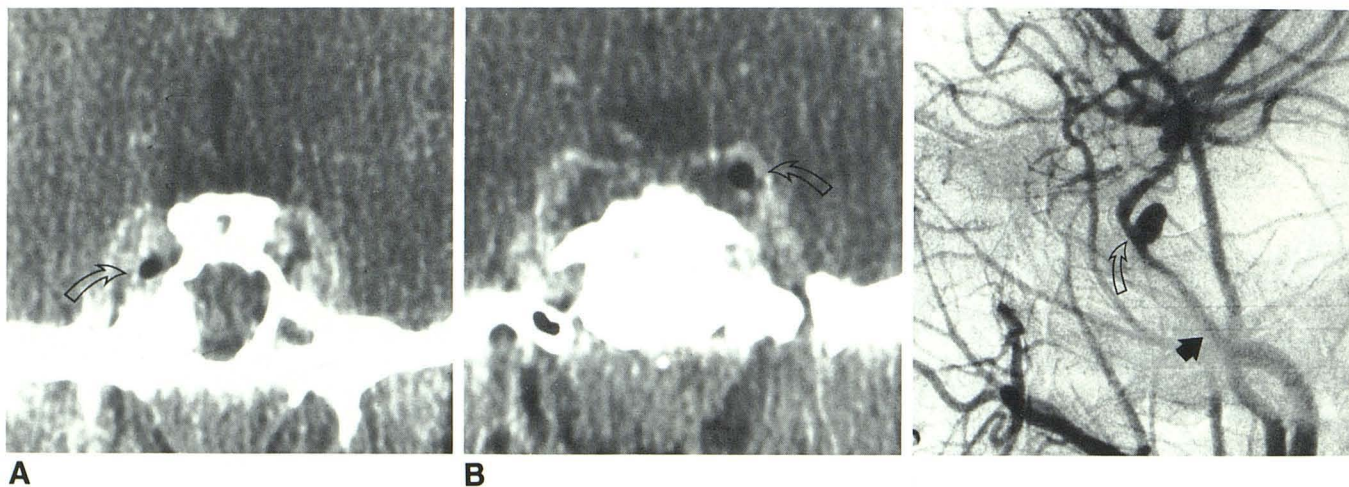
A, Coronal CT scan with contrast infusion shows air within right cavernous sinus (arrow), bulging of sinus walls, and opacity of sphenoid sinus.
